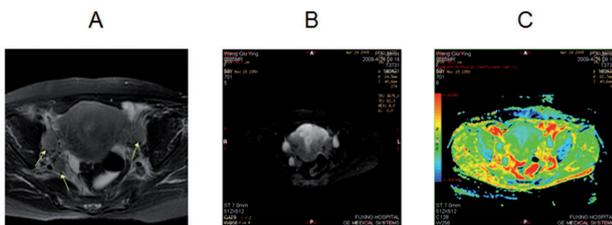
Poorly-differentiated endometrioid adenocarcinoma (grade 3). (a) Axial T2-weighted image shows a mass of intermediate signal intensity in the endometrial cavity and the whole myometrium with reactive lymph nodes (arrow). The exact extent of the tumor is not clearly recognized in this image due to poor contrast between the tumor and the adjacent myometrium. (b) DWI shows the extent of the tumor more clearly. (c) ADC map image demonstrates the tumor as a prominent hypointense area compared with normal parenchyma.
